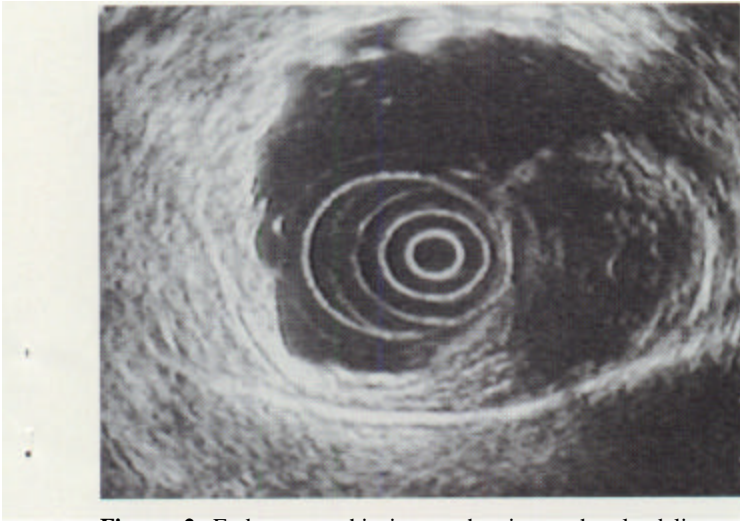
Endosonographic image showing a sharply delineated hypoechoic lesion. The origin of the submucosal tumor from the muscularis propria suggests a leiomyoma. No vascular structures were seen within or surrounding the tumor.
